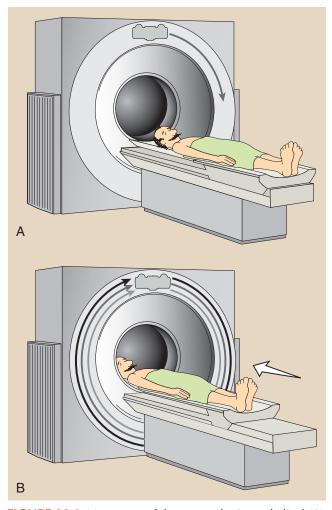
Movement of the x-ray tube is not helical (A). It just appears that way because the patient moves through the plane of rotation during imaging (B).
